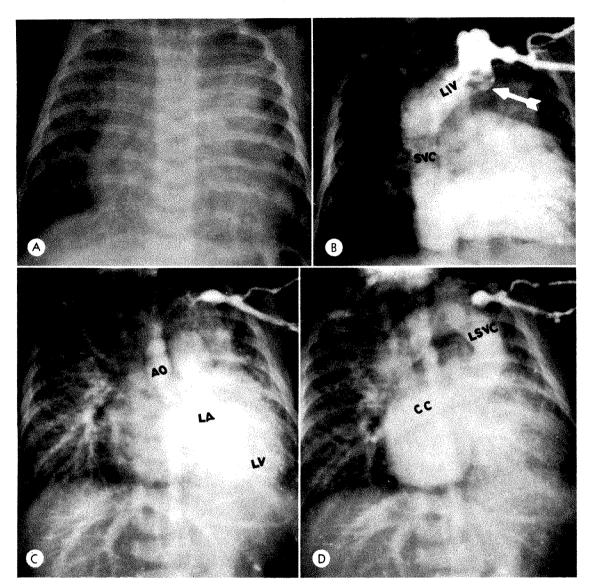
Case 16. Total drainage of the pulmonary veins into the left innominate vein. (A) Frontal roentgenogram of a two month old infant exhibiting enlargement of the heart and supracardiac structures. (B) In the frontal angiocardiogram the left innominate vein (LIV) contains a jet (arrow) and the superior vena cava (SVC) is dilated. (C) The angiocardiogram taken immediately after B shows opacification of a small left atrium (LA), left ventricle (LV) and aorta (AO). (D) A later frontal angiocardiogram shows a common channel (CC) collecting blood from the right and left pulmonary veins and proceeding via a left superior vena cava (LSVC) to reopacify the left innominate vein and the right superior vena cava.
